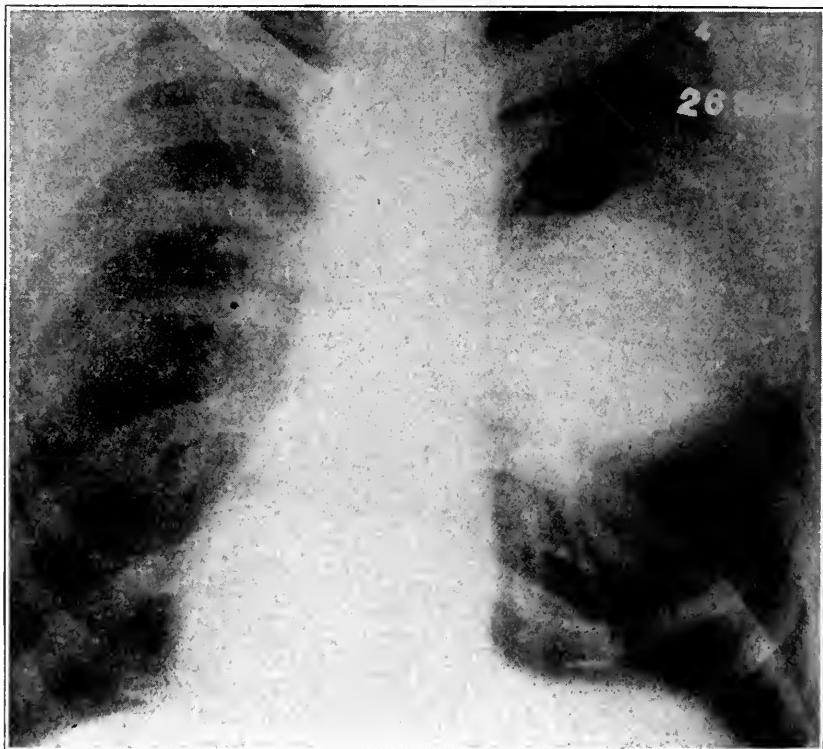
(Case 269244)—Roentgenogram of adenocarcinoma of lung and breast shown in Figure 10.
